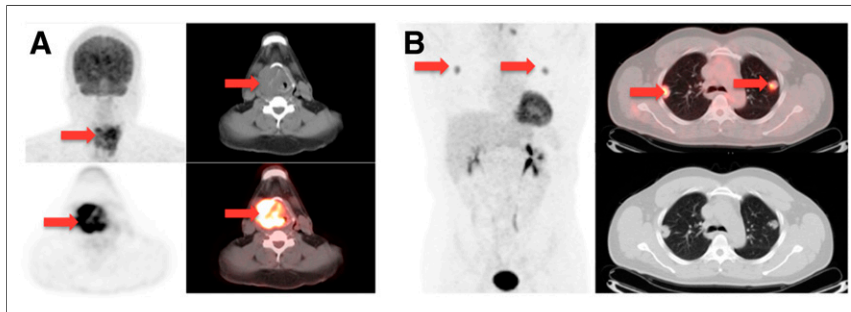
Positive PET/CT scan at 12–24 mo of follow-up in 43-y-old man with history of T4N2bM0 squamous cell carcinoma of supraglottic larynx. (A) Baseline coronal and axial PET (bottom left), axial CT (top right), and fused PET/CT (bottom left) show supraglottic mass (arrows). Patient underwent laryngectomy and right neck dissection. He then completed course of cisplatin and radiation to 66 Gy. (B) At 13 mo after therapy, follow-up PET/CT, not presented here, showed locoregional recurrence in neck; maximum intensity projection 3-dimensional representation (left), axial CT (bottom right), and fused PET/CT (top right) sections showed metastatic disease to lung upper lobes (arrows).
